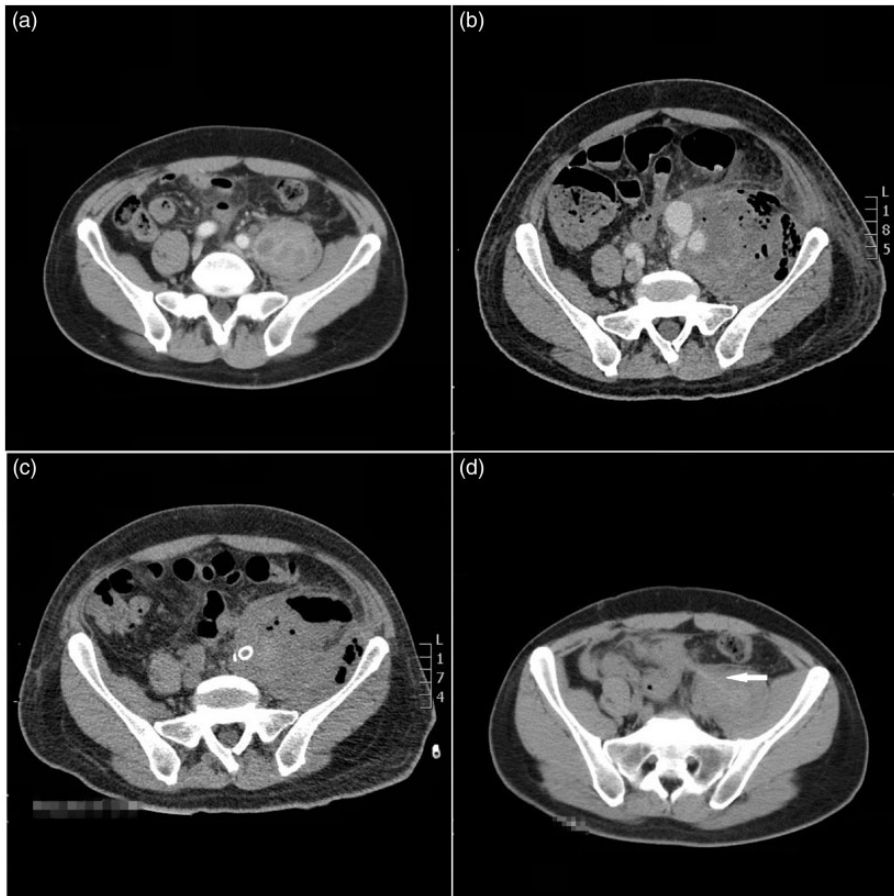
(a) Contrast-enhanced computed tomographic image of a left psoas abscess 2 weeks before admission. (b) Contrast-enhanced computed tomography on admission showing enlargement of the abscess and a newly developed left iliac artery rupture. (c) Non-enhanced computed tomographic scan taken 2 weeks after the initial angiography showing that percutaneous abscess drainage is inadequate. (d) Review of a computed tomographic scan performed 2 weeks before admission shows a toothpick in front of the left external iliac artery (arrow).
